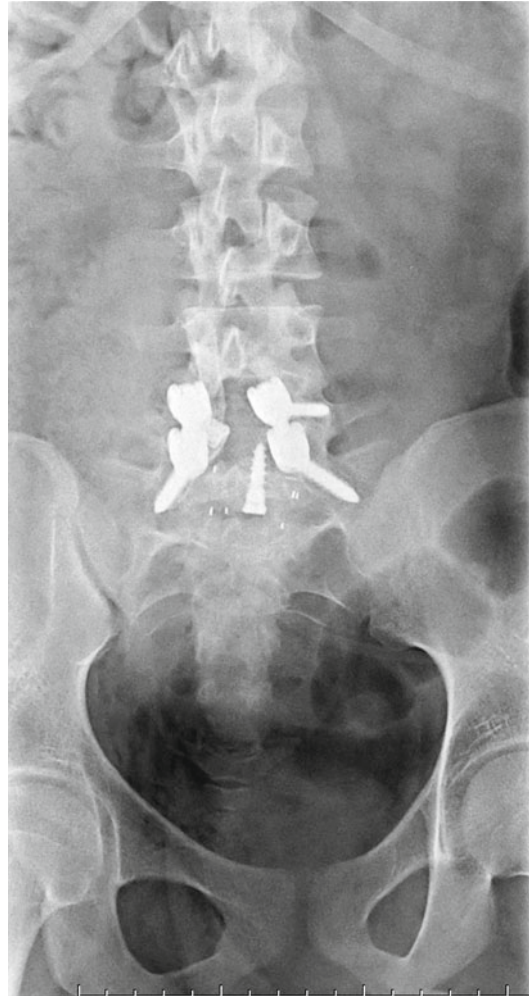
Anterior-posterior radiograph of the lumbar spine showing the instrumentation construct of the spinal fusion
